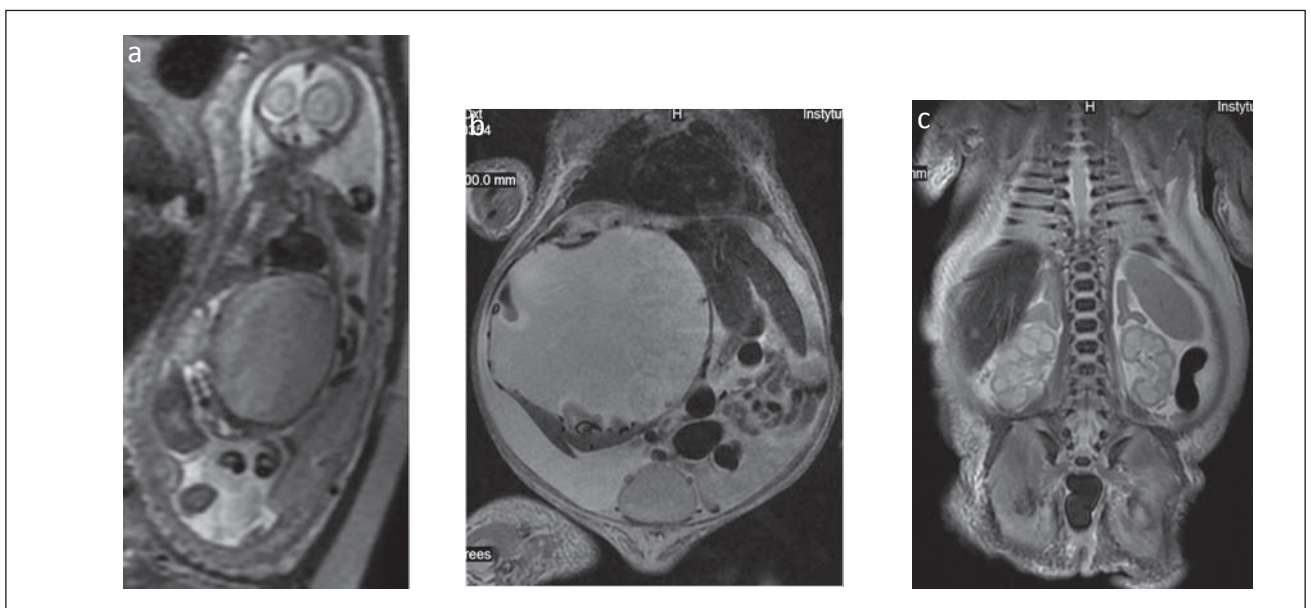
Blue rubber bleb nevus syndrome in a 25-week fetus (a) and in a newborn on the second day of life (b,c). The huge abdominal and pelvic cyst could have been properly named neither on the basis of fetal MRI (a) nor on postnatal examination (b,c). The additional nodules (here in the right lobe of the liver – c) suggested diagnosis of a malignant tumour with metastatic spread.
